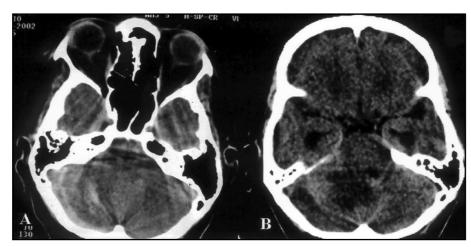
Axial cut of the first (A) CT, showing a hyperdense area in the right cerebellar hemisphere, and the second (B), fifteen days later, showing the dilated temporal horns and a hypodense area in the same cerebellar hemisphere.
